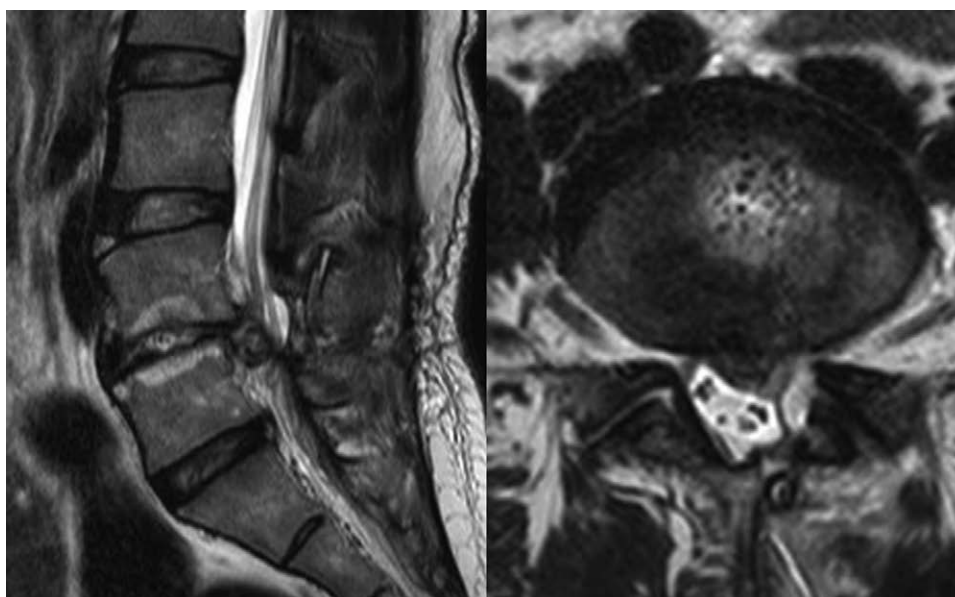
MRI positive case. Immediate, postoperative MRI in a patient who underwent partial hemilaminectomy and discectomy for a herniated lumbar disc showed that a disc left in the 4 to 5 lumbar spine on the MRI caused symptoms. MRI = magnetic resonance imaging.
